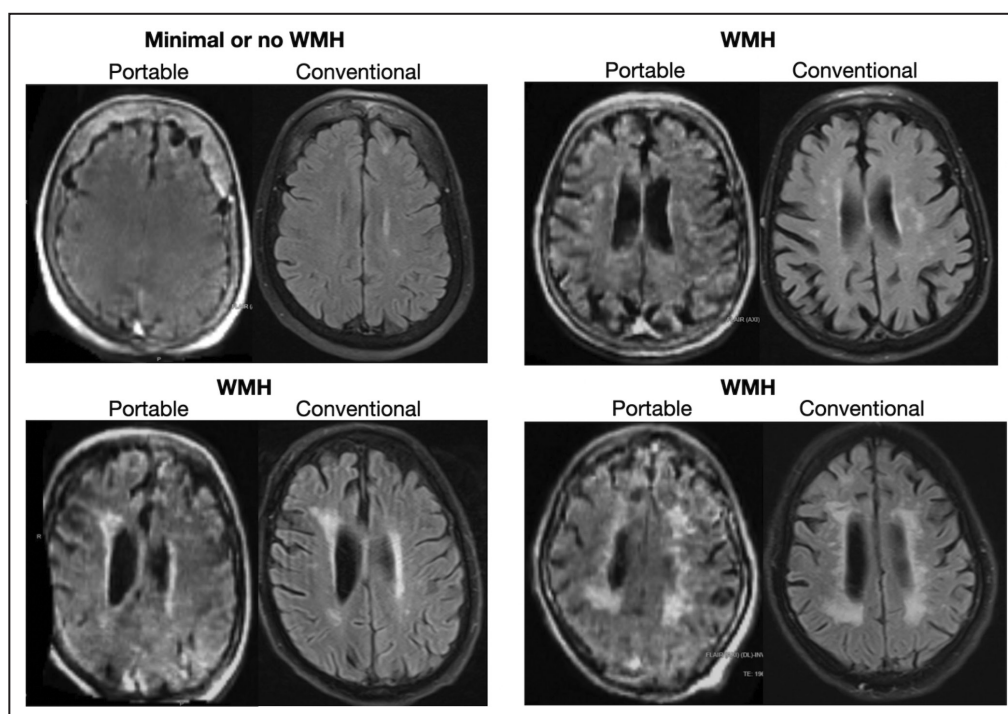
An example of patients with a portable and conventional magnetic resonance imaging showing minimal appreciable burden of WMH (top left) and examples of WMH on both modalities. WMH indicates white matter hyperintensity.
